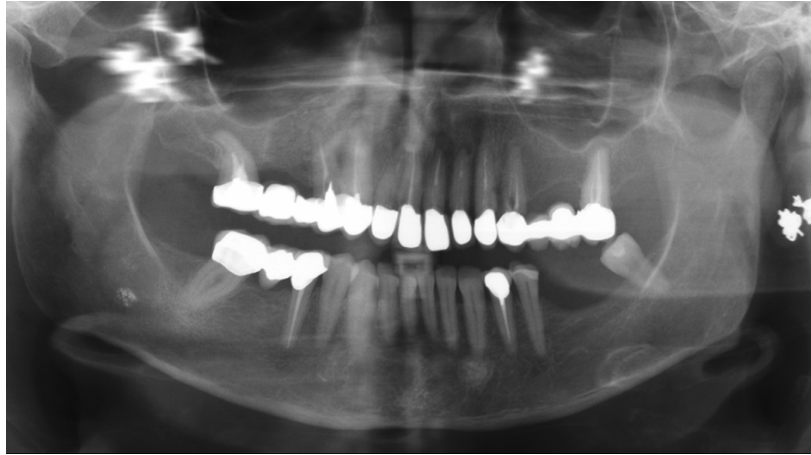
Initial panoramic X-ray showing non-recoverable teeth in the upper arch
